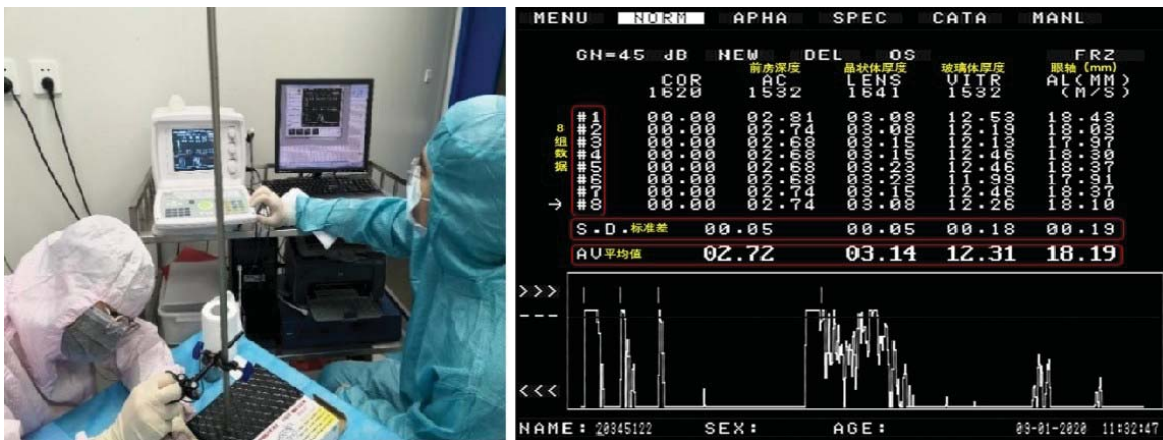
Ophthalmology A-ultrasound inspection site (left) and screenshot of A-ultrasound test results in automatic mode
